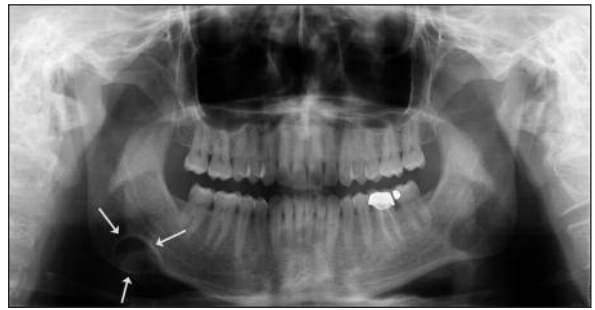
Panoramic radiography reveals a large radiolucent lesion on the right side of the mandible.
